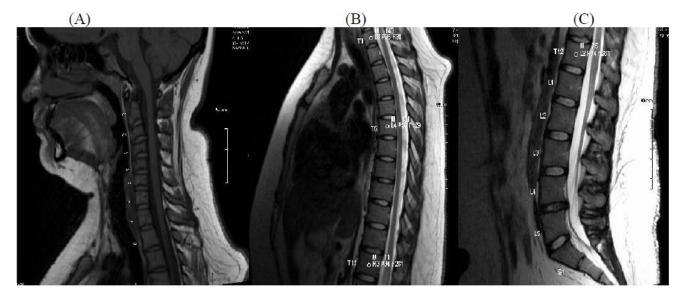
MRI of Cervical (A), Thoracic (B) and Lumbar Spine (C) shows normal anatomy
